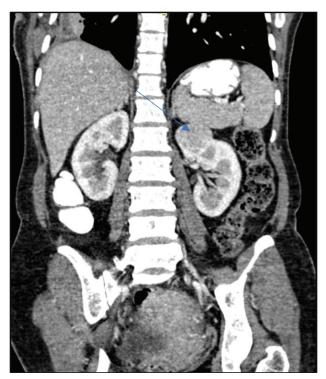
CT abdomen showing renal mass at upper pole of left kidney.
